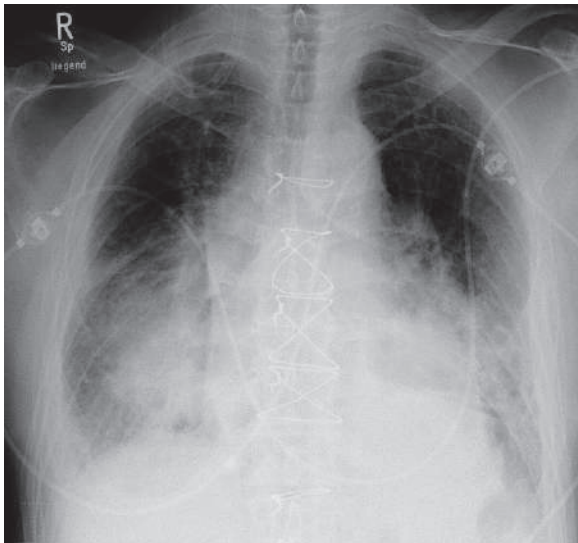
Anteroposterior chest radiograph of a patient with bone marrow transplant due to leukemia who developed COP shows bilateral patchy infiltrations located at the lung bases with peripheral patchy infiltration
